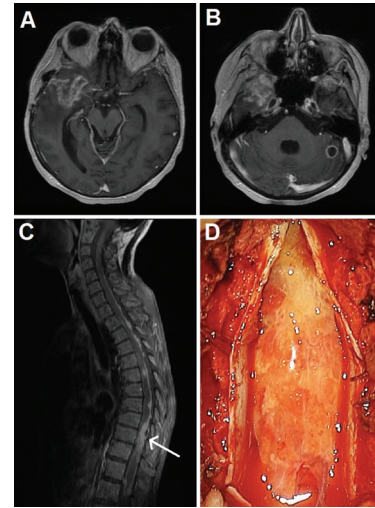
A: T1-weighted axial MRI scan after gadolinium showing enlargement of the residual tumour in the right temporal lobe. B: T1-weighted axial MRI scan after gadolinium showing a new tumour in the left cerebellar hemisphere. C: T2-weighted MRI sagittal scan with fat suppression showing spinal seeding with nodules on the dorsal surface of the spinal cord and intraspinal tumour mass (arrow). D: Intraoperative view after laminectomy T9–10; pathologically thickened and altered spinal cord with metastatic tumour.
